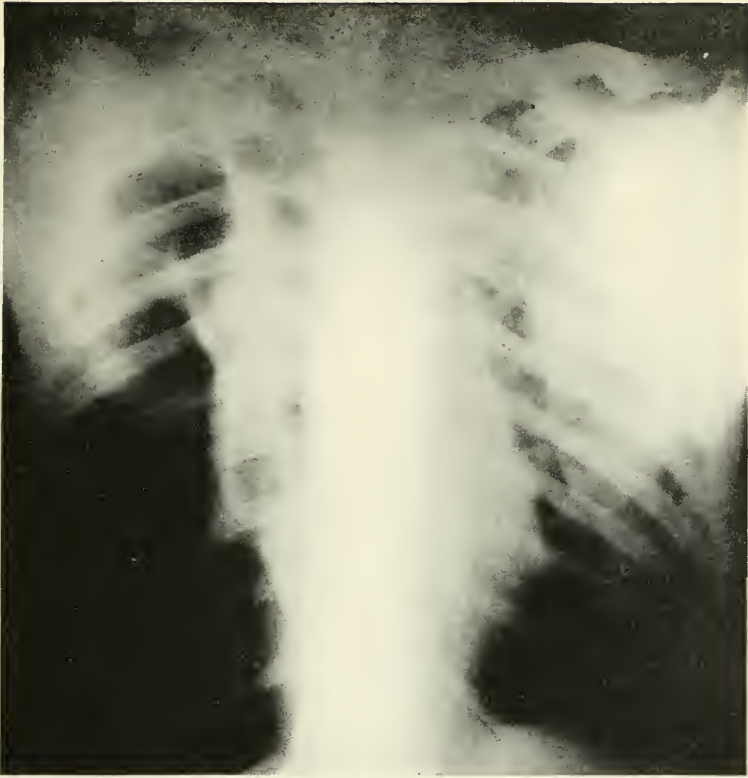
ROENTGENOGRAM OF CHEST OF PATIENT WITH DOUBLE PNEUMOTHORAX.
